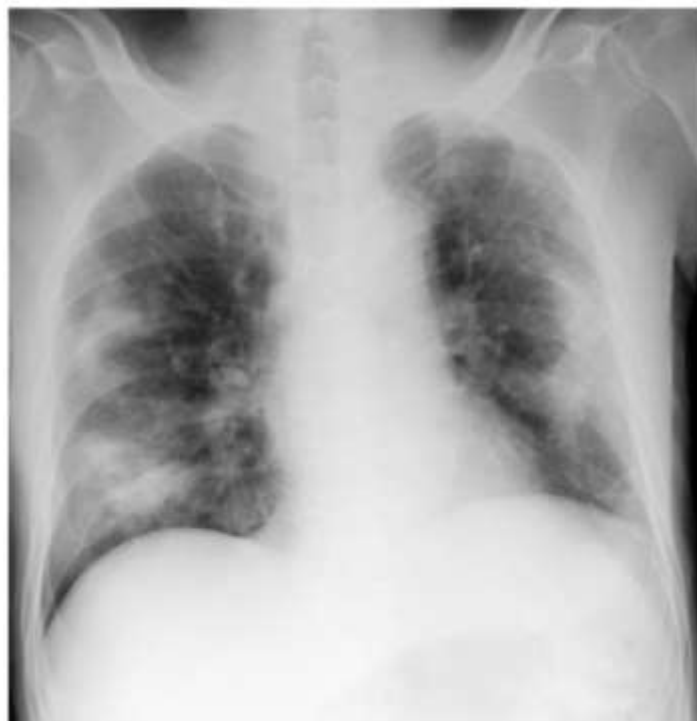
Chest X-ray on admission showed an infiltration shadow in the bilateral middle and lower lung fields
